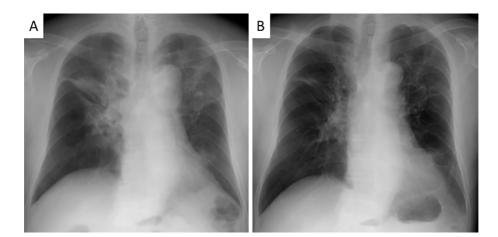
The changes in the chest X-ray findings during the clinical course. (A) At the time of the diagnosis, bilateral consolidation, predominantly in the upper lung field, was indicated. (B) The consolidation gradually resolved after avoiding exposure to titanium for four years.
